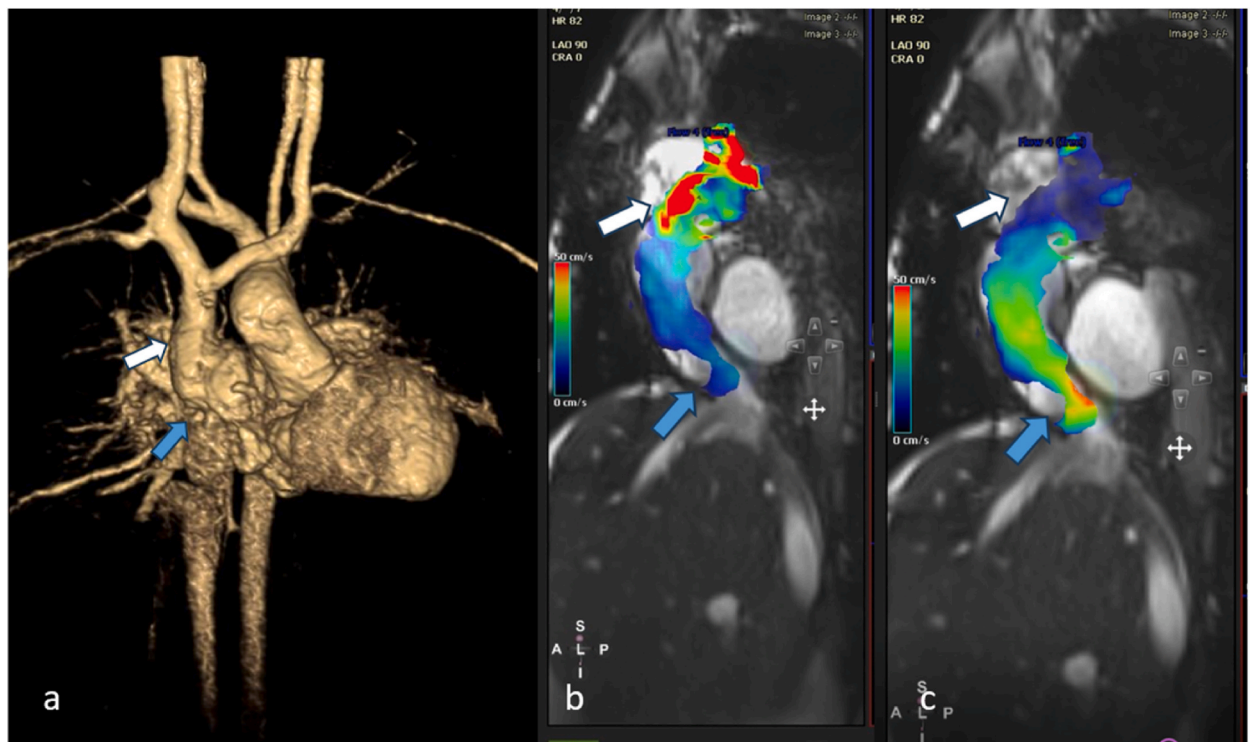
MRI analysis sequence snapshots for this patient are provided. Increased blood flow velocity at the two sites of the Fontan circulation was observed as red color coded regions. Proximity of these regions correspond to high spatial velocity gradients (a) 3D MRI images of the patient IVC-Fontan anastomosis is marked with blue arrow and Fontan tube is marked with white arrow. Markers indicate the high flow velocity values quantitatively. (b) Disturbed, unstable blood flow encoded in red color at the site of the left pulmonary artery and Fontan tube connection (white arrow) (c) Flow across the inferior vena cava also reported high velocity values (blue arrow).
